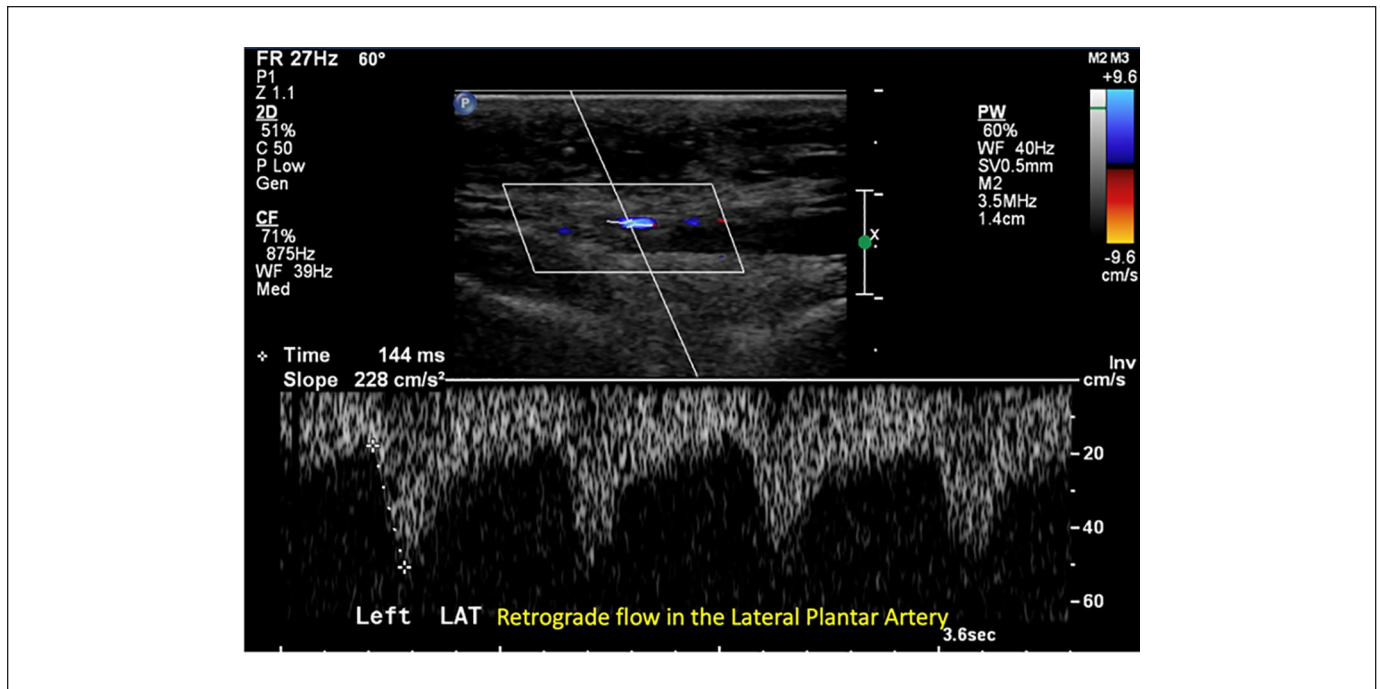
Spectral doppler indicating retrograde flow in the lateral plantar artery via the arcuate artery (anterior circulation).
